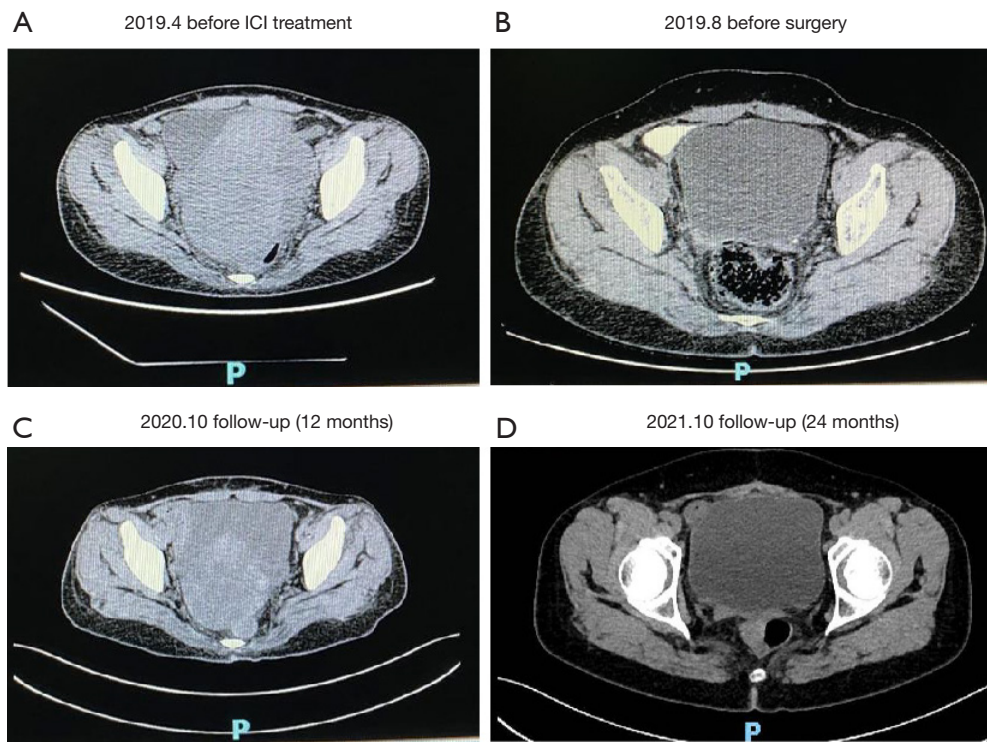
Treatment evaluation by CT scans. (A) Before ICI treatment; (B) before surgical resection; (C) 12 months after surgery; (D) 24 months after surgery. ICI, immune checkpoint inhibitor; CT, computed tomography.
